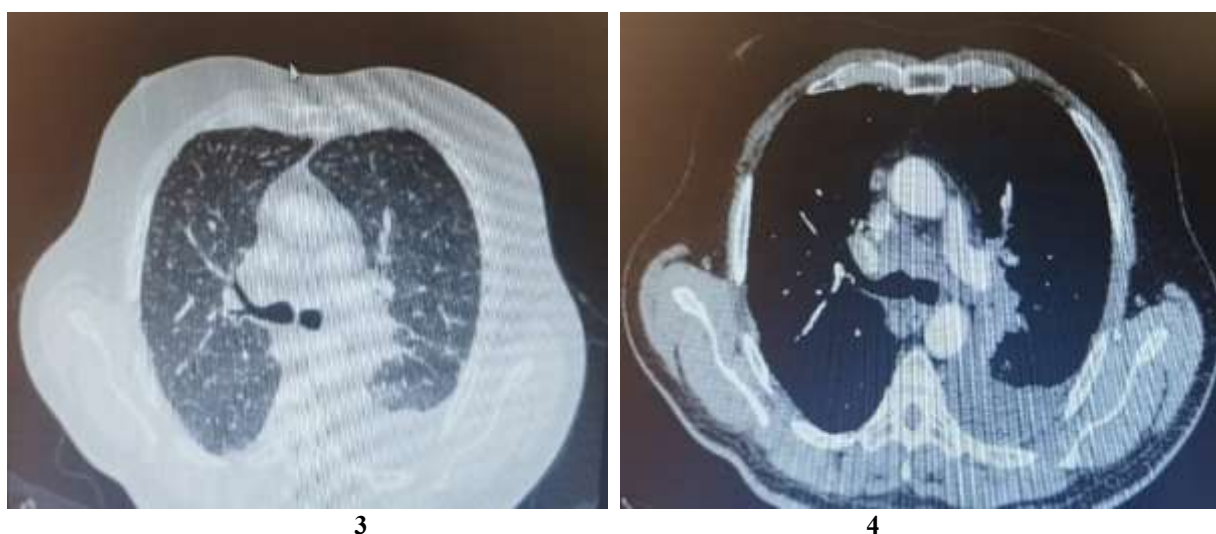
Contrast enhanced CT showing multiple infiltrates of the parenchyma (3) and mediastinal and hilar lymphadenopathy with pleural effusion (4)
